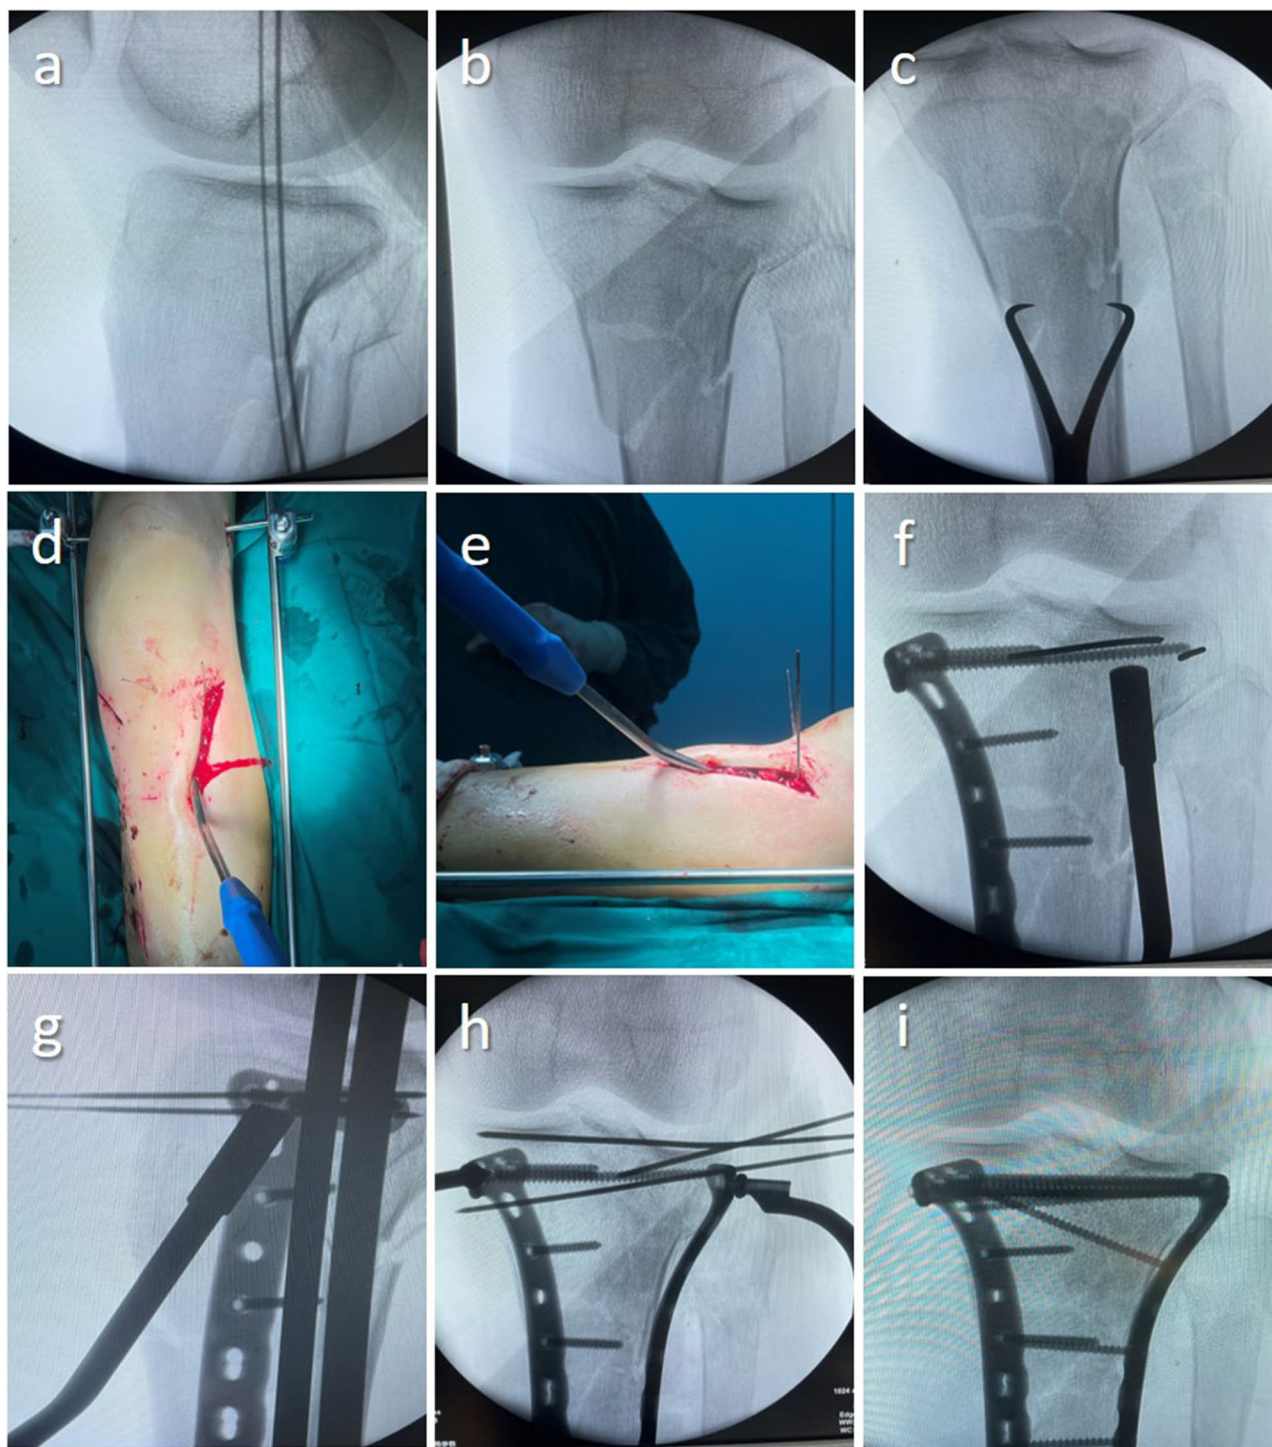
Preoperative X-ray showing an AO/OTA 41C2 TPF involving the posterior column. (a-b) A temporary bi-frame fixator, with limited incision and reduction and a bone tamp were used during the operation. (c-g). After fracture reduction, plates was inserted for fixation. (h-i)
